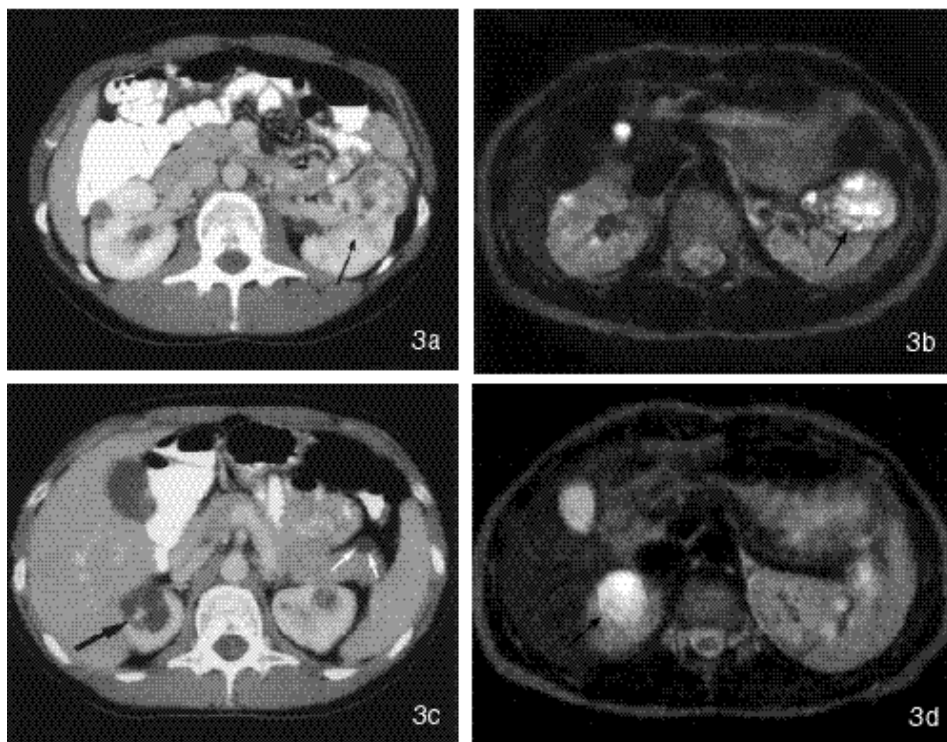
Comparison of CT and MRI of a RCC in a 27-year old woman with VHL disease. Monitoring was started two years before these imaging results. US showed a left-sided tumour of 3 cm in diameter. a CT shows a large cystic tumour in the left kidney (arrow). b MRI (TR/TE = 2475/100 ms) shows the pseudocapsule (arrow) better than CT. Note the cortical cysts in the right kidney. Despite the tumour size of 5x5x3 cm, nephron sparing surgery was able to be performed. During operation, major haemorrhage of the wound bed of the left kidney could be treated. A small cystic part of the tumour reached the rim of resection, but enucleation was performed radically. The right kidney shows a more central cystic tumour on CT in c and MRI in d, which should be removed in the near future. Note the pancreatic cyst in the tail (small arrows) in c.
